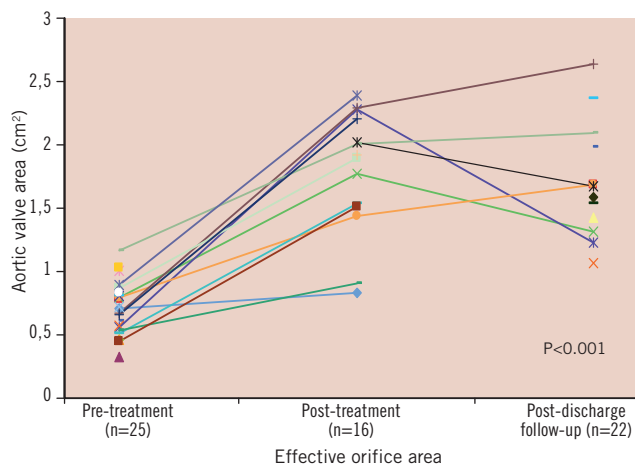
Effective orifice valve area ( $\text{cm}^2$ ) during serial echocardiographic evaluation ( $n$ =number of patient echocardiograms with sufficient information for assessment of effective orifice valve area).
